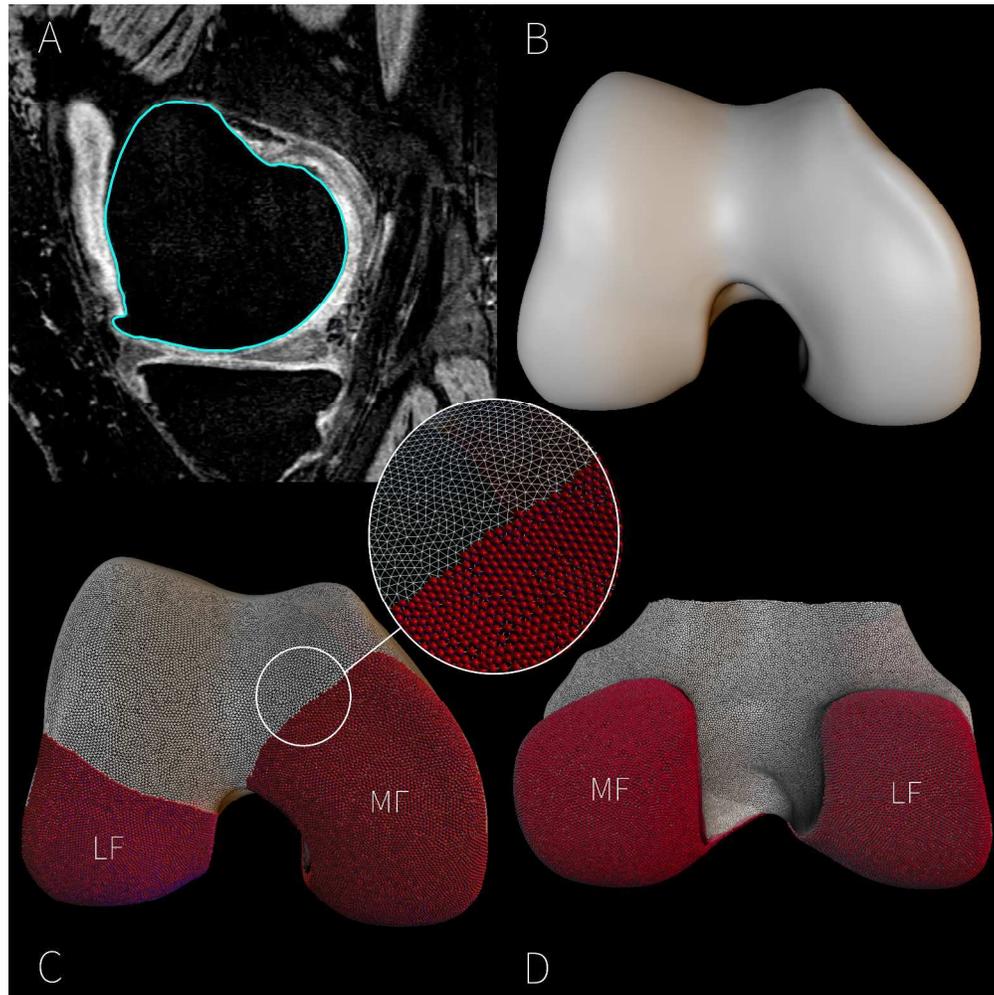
Automatic segmentation of MR images using active appearance models, and generation of anatomical regions
